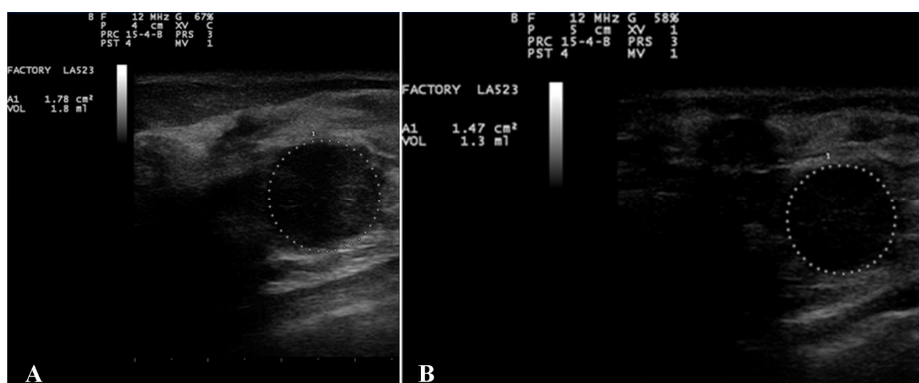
Ultrasonography of breast cancer. A 43-year-old woman was diagnosed with metastatic breast cancer to bone and liver in February 2013. After 1 week of integrative immunotherapy where OA-GcMAF (880 ng/day) was administered by localised subcutaneous injections, the primary tumour at the level of the breast, measured with ultrasonography, showed a decrease of calculated volume from 1.8 mL (panel A) to 1.3 mL (panel B). This corresponds to approximately a 28% overall reduction. This case was representative of four other cases of breast cancer that qualitatively gave similar results
